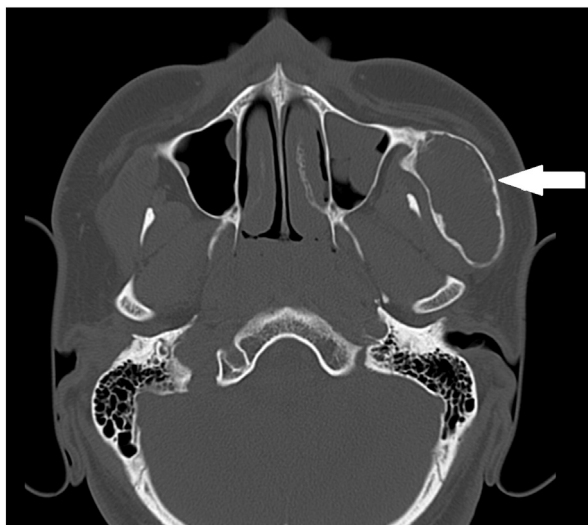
Axial CT scan shows the thin bone border of the lesion (arrow).
